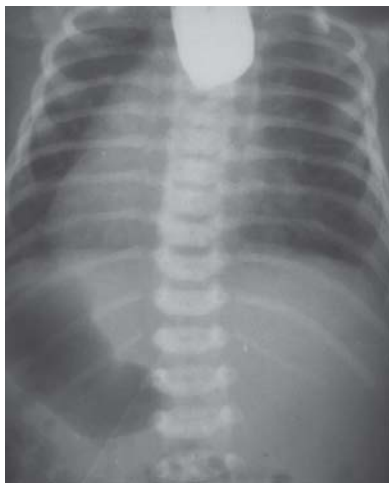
X-ray of the esophageal atresia with tracheoesophageal fistula in newborn with situs viscerum inversus (dextrocardia, stomach on the right side, esophagus ending in a blind-ended pouch)
